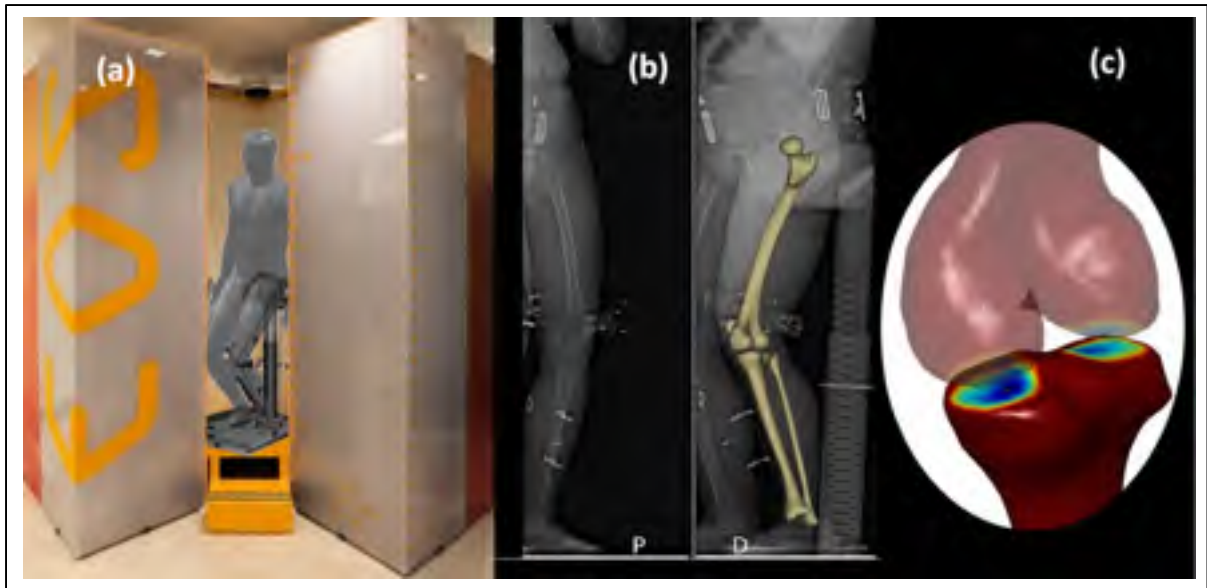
(a) Subjects performed a quasi-static squat assisted by a positioning jig standardized to put the knee in desired flexion angles. 5 pairs of orthogonal X-ray images of the lower limb at 0°, 15°, 30°, 45°, and 70° of knee flexion were recorded. (b) Bones were reconstructed from bi-planar X-ray images and registered to each of the 5 squat positions the subjects adopt in the EOS® system cabinet. (c) 2 pairs of points on the medial and lateral sides of the tibia and femur represented CPs and minimum tibio-femoral bone-to-bone distances.
